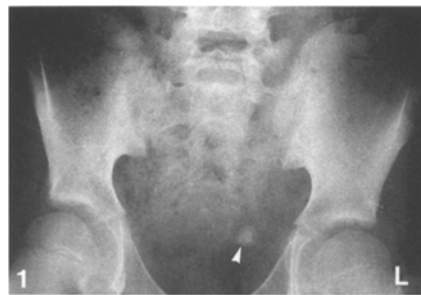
Radiograph of the pelvis showing lamellated calculus (arrow) projected over bladder area
